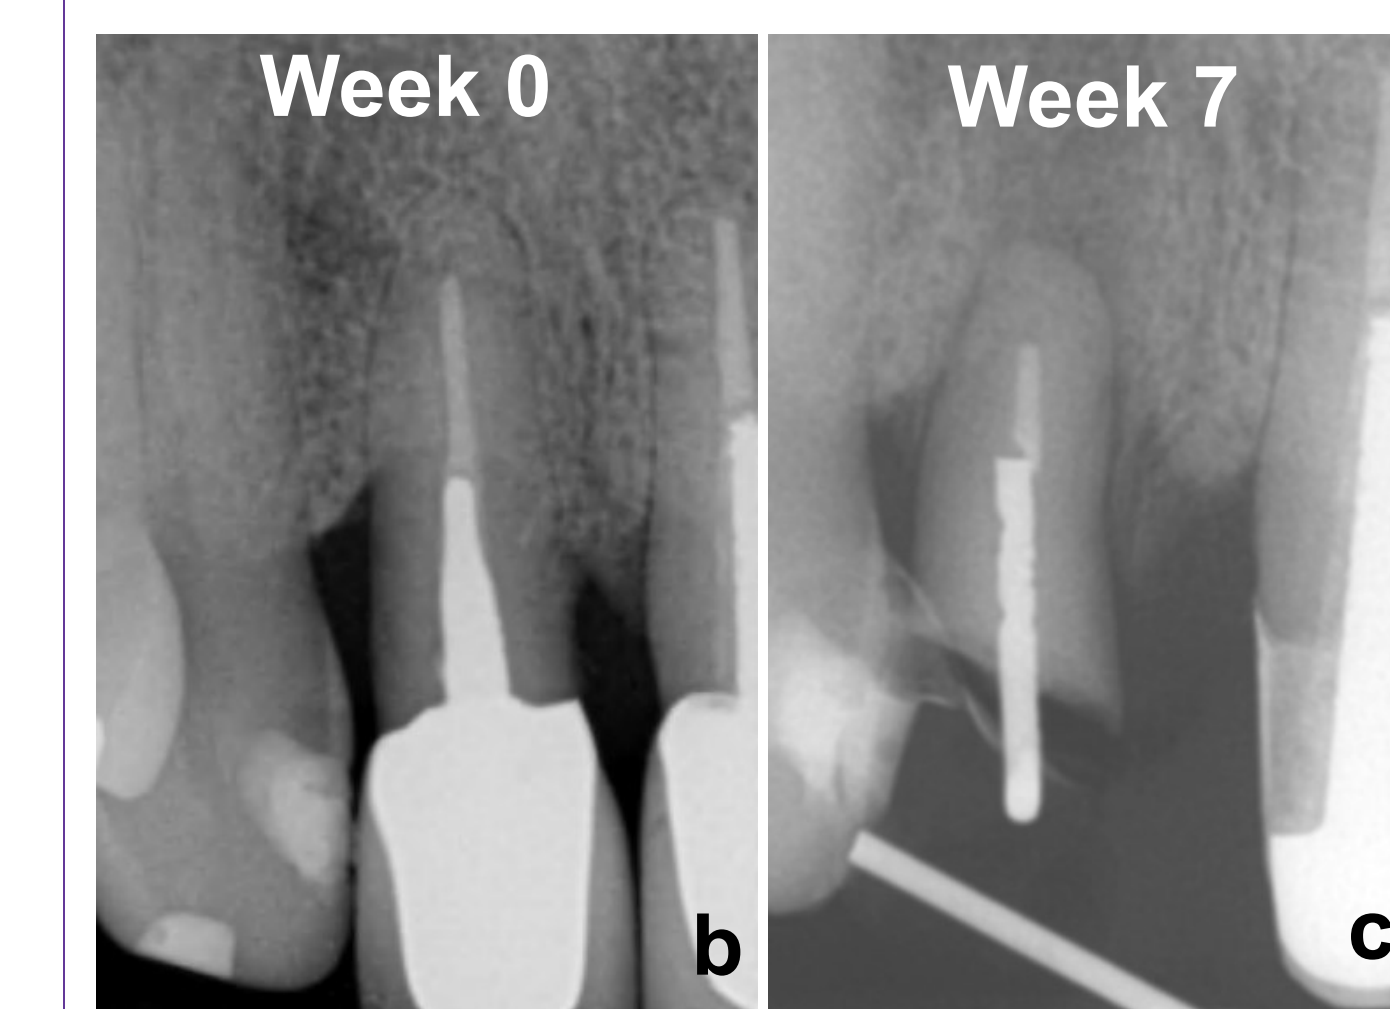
Pre-op and post-op comparisons of #7 bone and soft tissue level after forced eruption. a: Superimposition of #7 gingival margin before and after forced eruption shows gain of soft tissue coronally as outlined in white. b, c: #7 periapical radiographs at week 0 and week 7, respectively. Premature bone formation was observed interproximally at week 7 of forced eruption.
